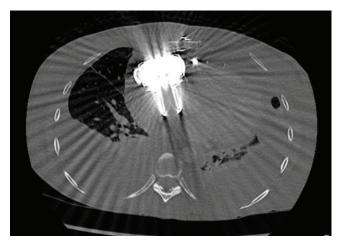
Computed tomography scan image shows the left ventricular assist device anterior to the right atrium. It is connected to the left atrium through the right atrium via a Gore-Tex[®] conduit.
